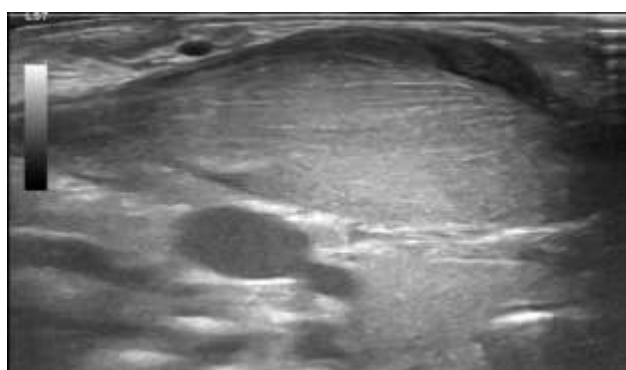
Diffuse isoechoic fusiform/ellipsoid enlargement within the boundaries of right SCM superior to right lobe of thyroid with minimal internal vascularity on colour Doppler, however fibrillation pattern is well maintained. The left SCM appears unremarkable.
